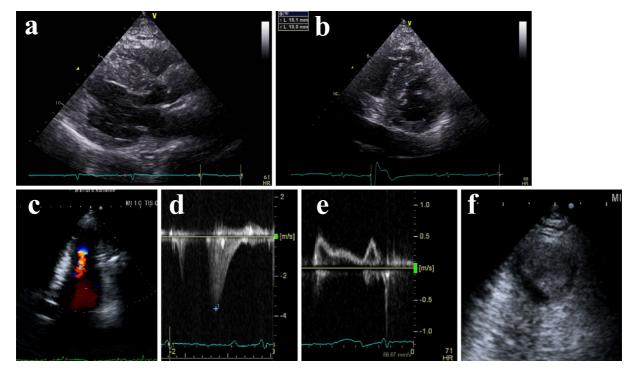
The echocardiogram obtained at admission is shown. The echocardiogram in the parasternal long-axis view (a) and short-axis view (b) showed asymmetric septal hypertrophy. A paradoxical jet flow from the apex toward the base of the left ventricle was observed during early diastole (c). This accelerated flow in the midventricle showed a peak velocity of 2.00 m/s at systole and 3.67 m/s at diastole (d). The E/A velocity ratio was 1.12, showing a pseudonormal transmitral flow pattern (e). Furthermore, echocardiogram revealed an apex aneurysm and thrombosis measuring 21×14 mm (f).
